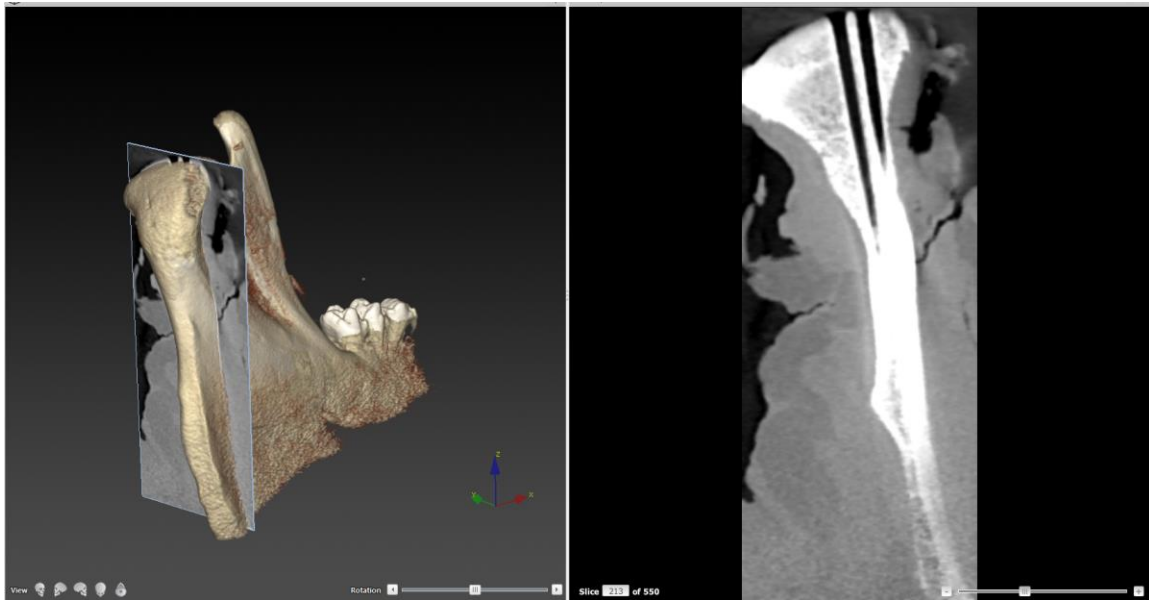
Bone tissue optical property characterization. CBCT imaging of osteotomies in DTX software package.
